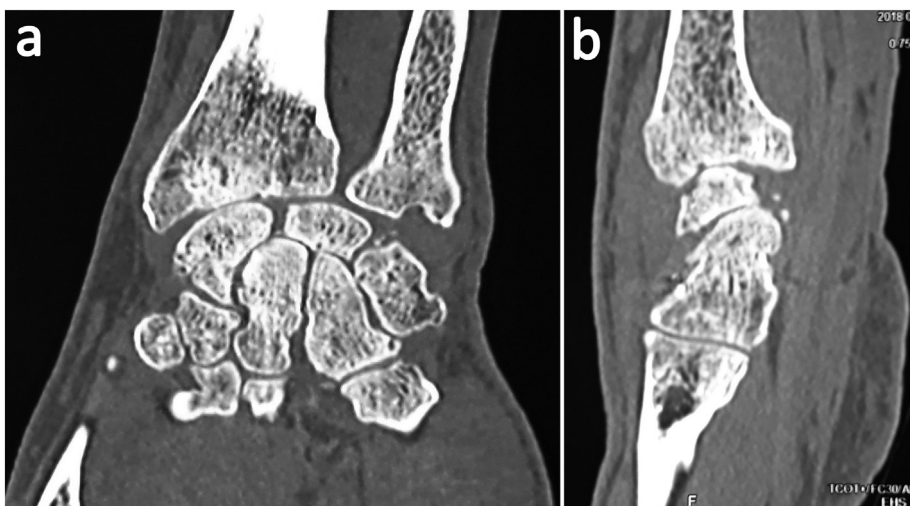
CT aspects 25 months after surgery in frontal (a) and sagittal (b) sections.
